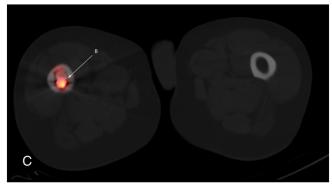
Loosening of both the acetabular and femoral stem components of a hip arthroplasty. Coronal (A), transverse superior (B), and transverse inferior (C) fused SPECT/CT images demonstrate activity between the bone–prosthetic interface of both the acetabular (arrow A) and femoral stem (arrow B) components.
